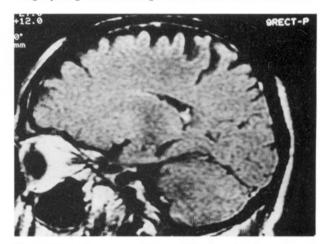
Magnetic resonance images of the bony involvement and dural irregularity.
